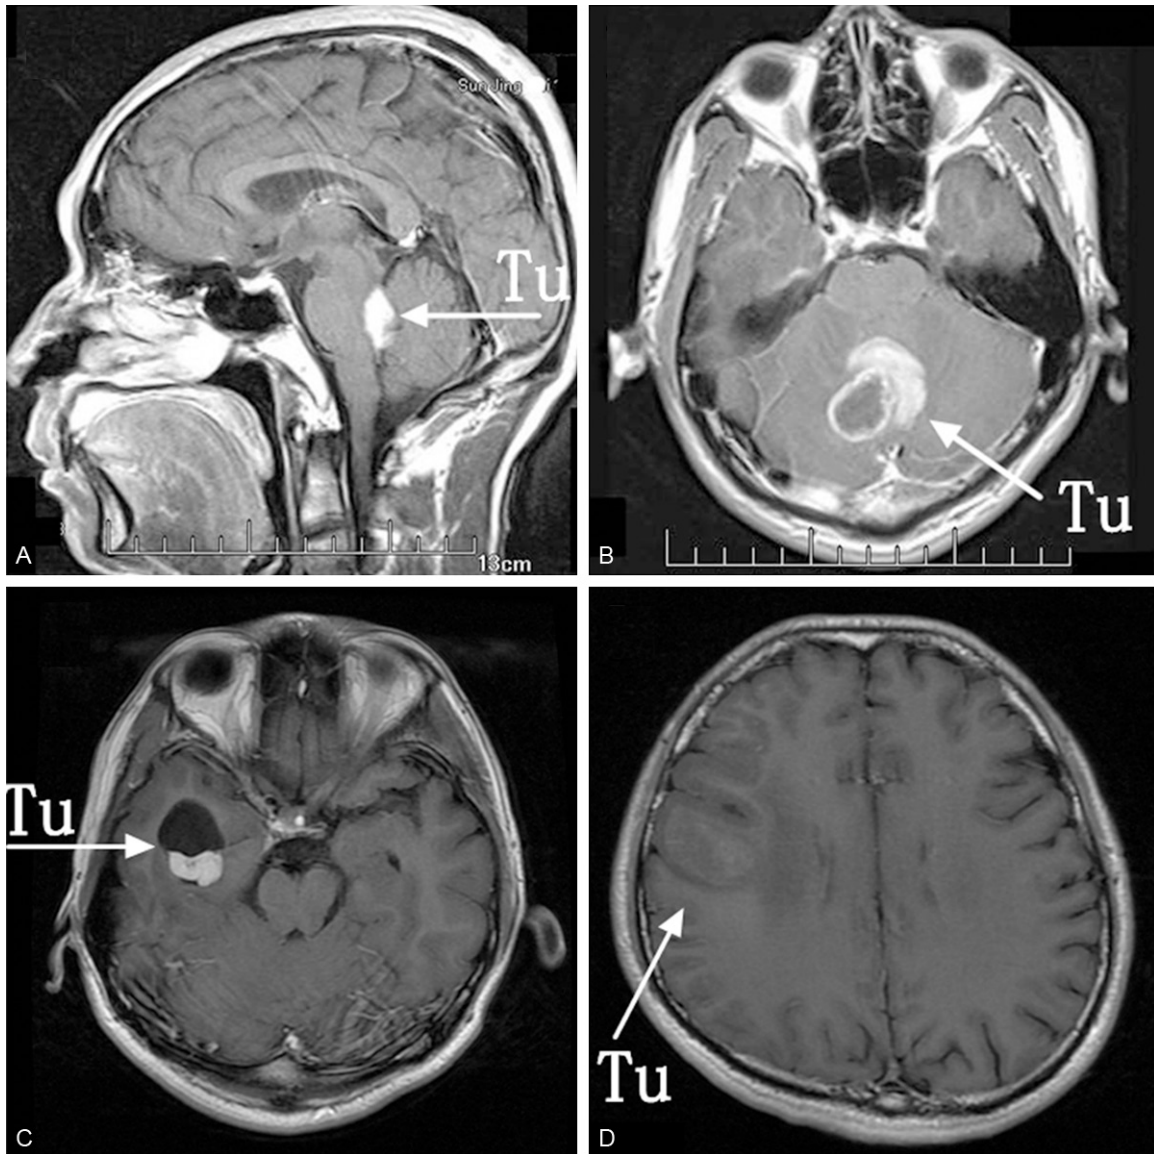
Representative MRI scans of two patients with atypical PXA (A, B) and two patients with typical PXA (C, D). Arrows show the tumor mass. Tu (tumor). (A) IV ventricle PXA; (B) Cerebellum vermis PXA; (C) Temporal lobe PXA show enhance tumor mass with cyst; (D) Parietal lobe mass with weak enhance.
